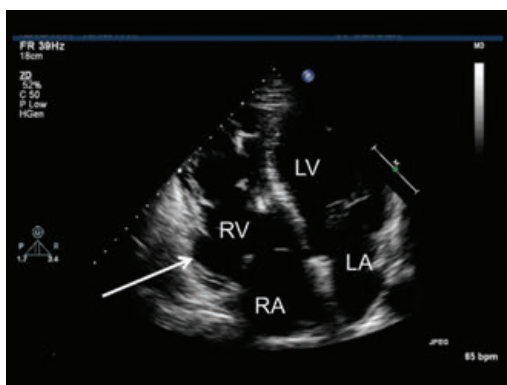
Transthoracic echocardiogram (apical 4-chamber view). The right ventricle (RV) and right atrium are enlarged and the RV presents with a paper-thin free wall; arrow depicts subtricuspid aneurysm. LV = left ventricle; RA = right atrium; RV = right ventricle.
